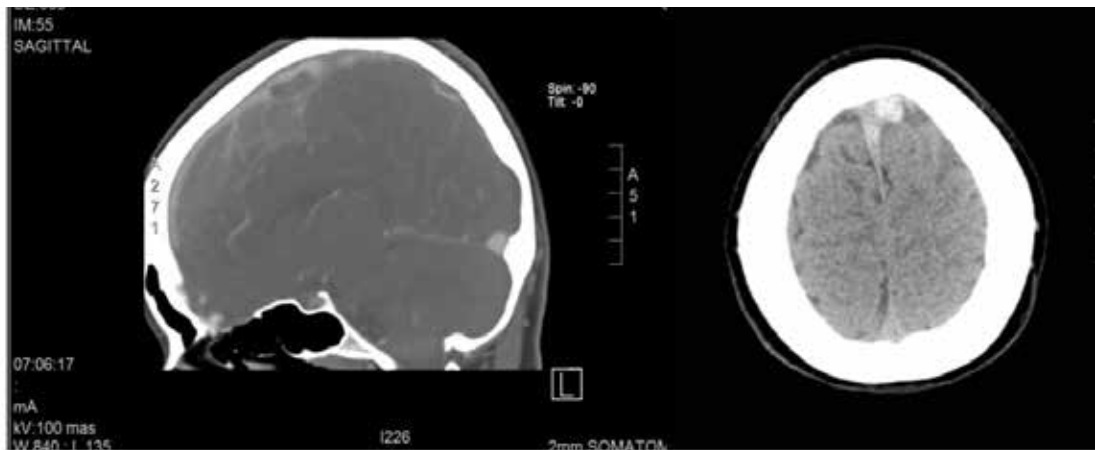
CT scan of head (sagittal and axial views) with contrast showing thrombus extending in superior sagittal sinus
